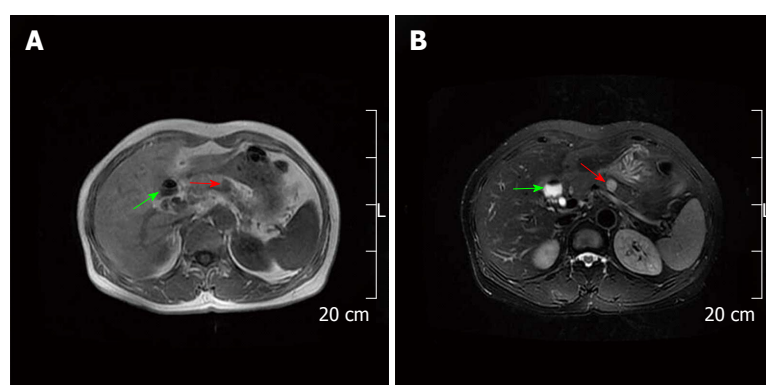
Magnetic resonance imaging findings. A: The mass in the pancreatic body (red arrow) and gallbladder (green arrow) appeared hypointense on T1 weighted images; B: The mass in the pancreatic body (red arrow) appeared inhomogeneously hyperintense and the enlarged gallbladder (green arrow) appeared hyperintense on T2 weighted images.
